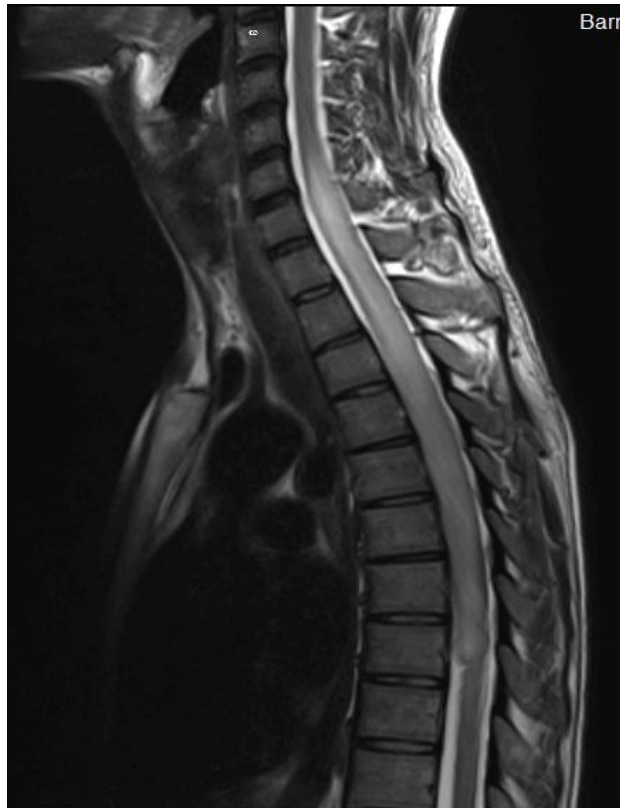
12 T2 WEIGHTED MRI shows – LONG SEGMENT INTRAMEDULLARY HYPERINTENSITY FROM C6-D8 LEVEL WITH MILD CORD EXPANSION.
